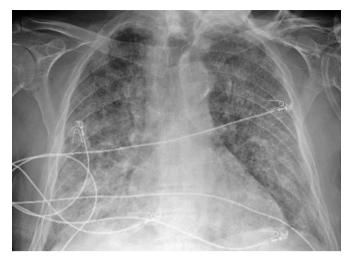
Chest X-ray shows diffuse bilateral infiltrates.
